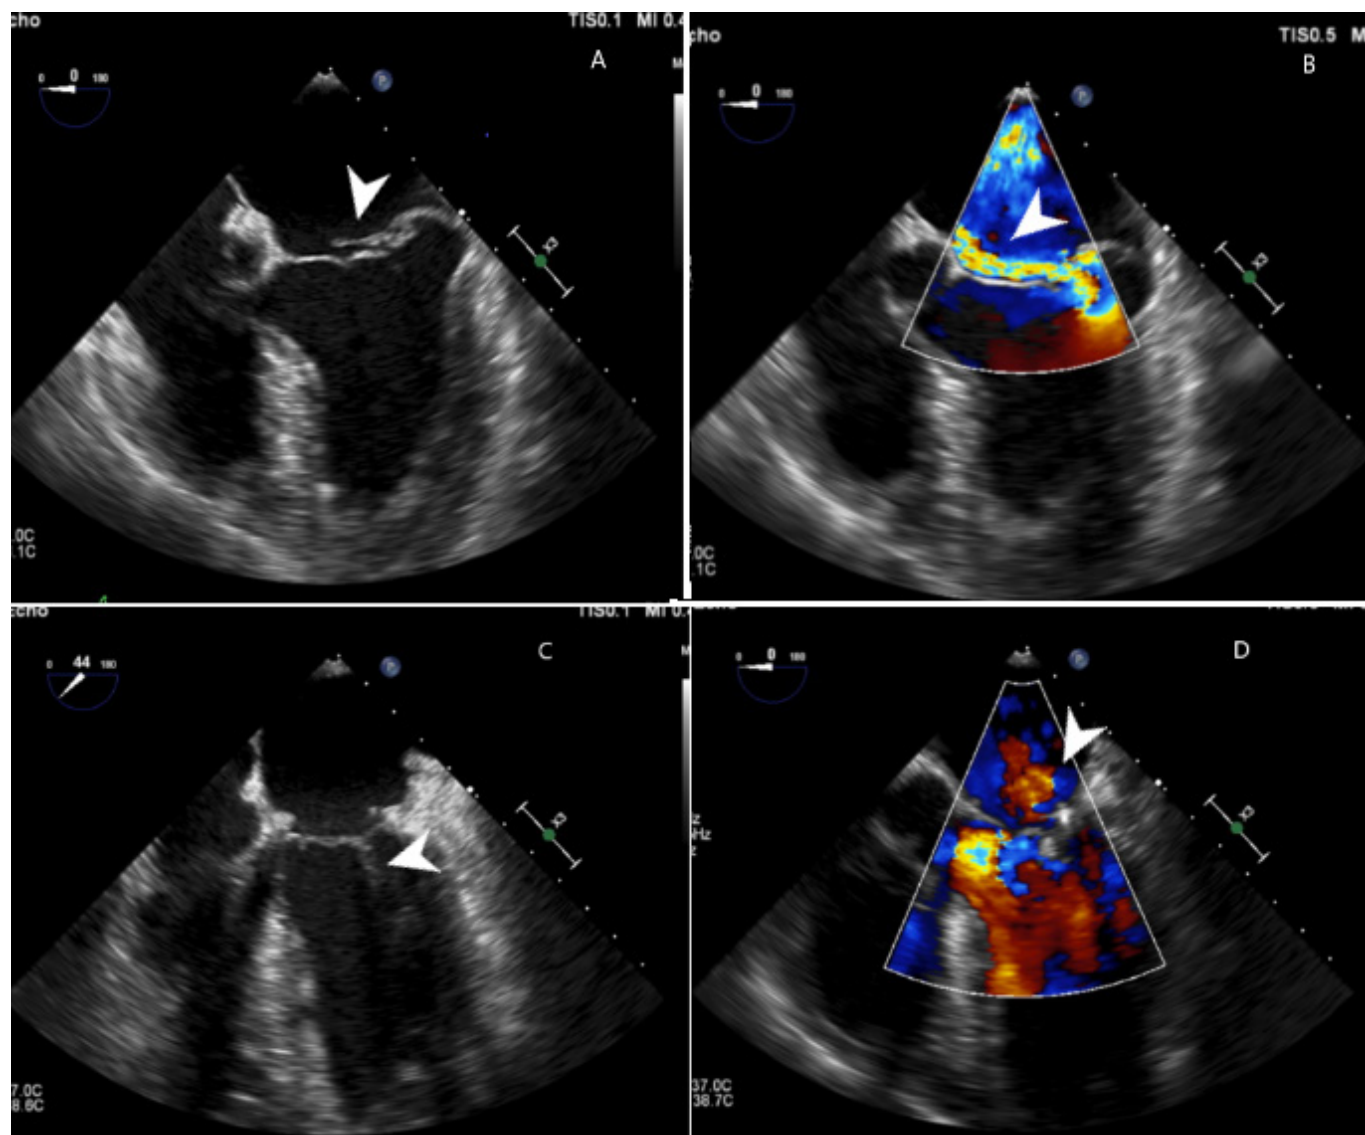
Transesophageal echocardiography. A: Preoperative evaluation shows fail of the posterior leaflet of the mitral valve with a significant coaptation deficit; B: Preoperative color Doppler reveals severe, eccentric regurgitation jet oriented towards the interatrial septum; C: Postoperative examination shows mitral valve coaptation line; D Postoperative color Doppler shows a mild mitral regurgitation
